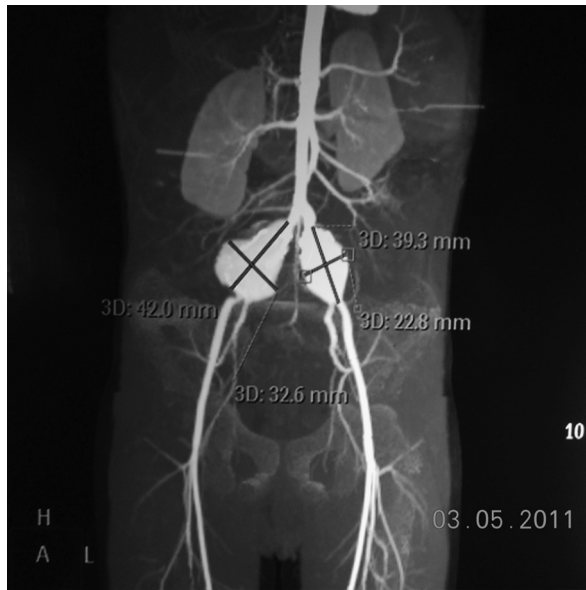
A preoperative computed tomography angiogram shows aneurysmal dilatation of both common iliac arteries.
